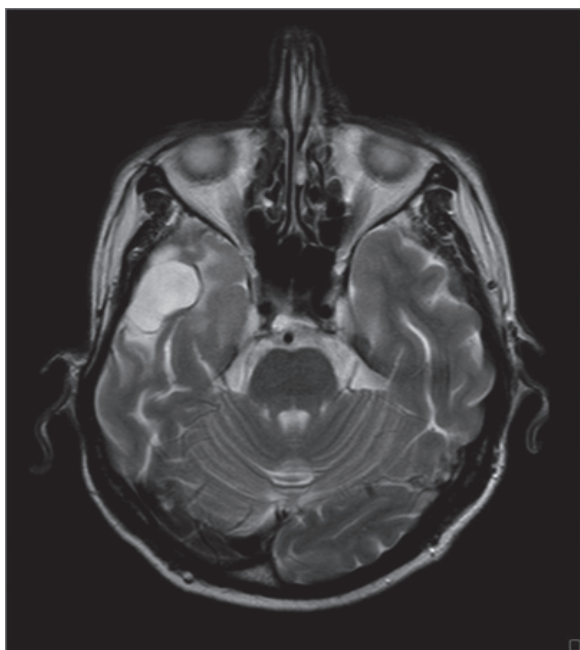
Last follow-up MRI — seven years after treatment. Axial T2-weighted image. Postoperative fluid-filled site with surrounding area of gliosis in the right temporal lobe
